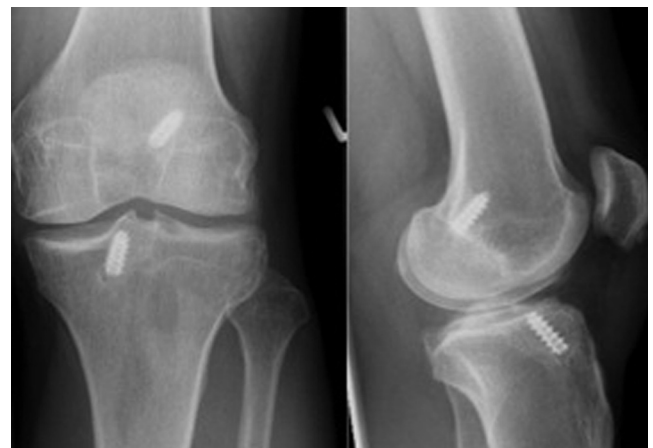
X-ray (AP and lateral standing) 17 years after ACL reconstruction of a 36-year old male patient. No severe osteoarthritic changes were observed.
